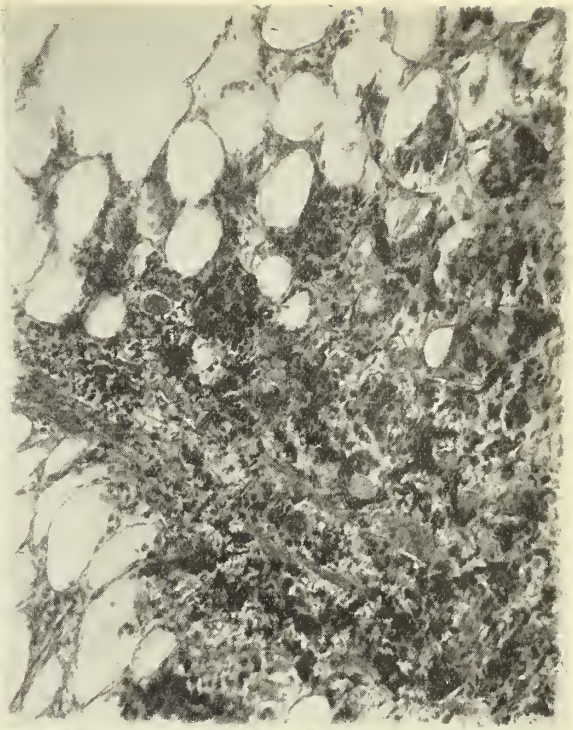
(*upper left*). Mrs. Wil. Operation February, 1926. This case is shown because of patient's age, *thirty-one years*. Scirrhous carcinoma; no axillary glands. Preoperative and postoperative irradiation. She still gets x-ray twice a year, though there are no signs of recurrence.
